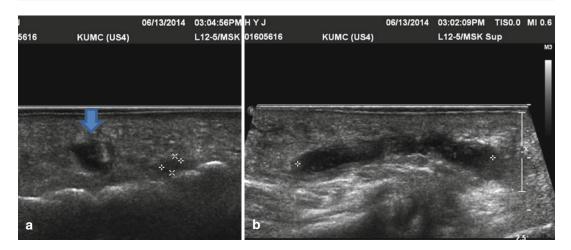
(a) Ultrasonography coronal view of intermetatarsal bursitis (*arrow*) and Morton's neuroma coexisting in a hallux valgus patient. (b) Intermetatarsal bursitis in the sagittal view (USG)
